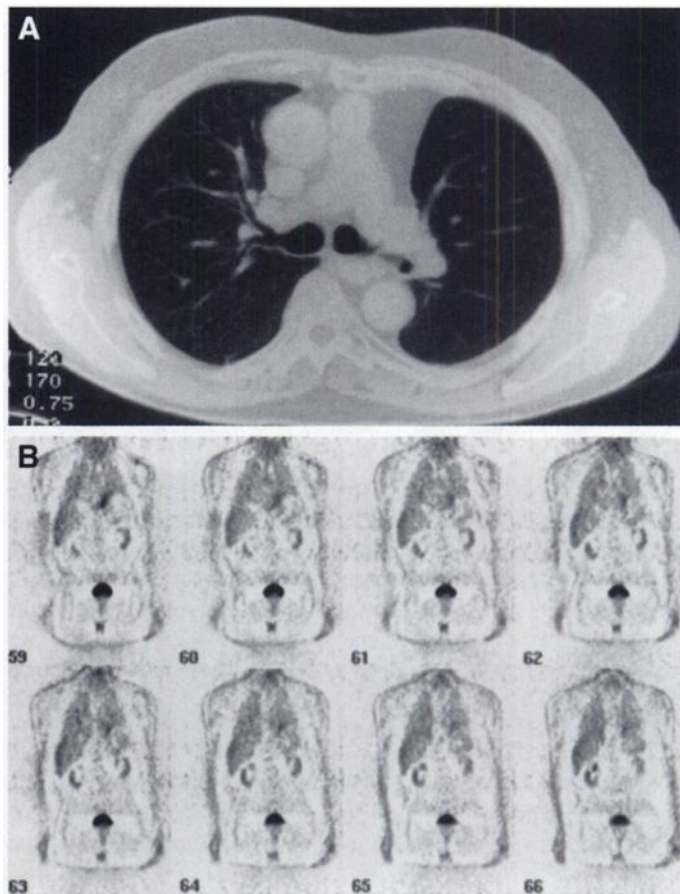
Follow-up imaging: (A) CT scan obtained 9 mo after surgery at the level of the right mainstem bronchus shows complete resolution of the right upper lung consolidation area. There also is no evidence of recurrence of previously resected left lung malignancy. (B) Eight sequential coronal whole-body FDG PET images acquired 11 mo after the original PET scan demonstrate no evidence of abnormal FDG uptake.
